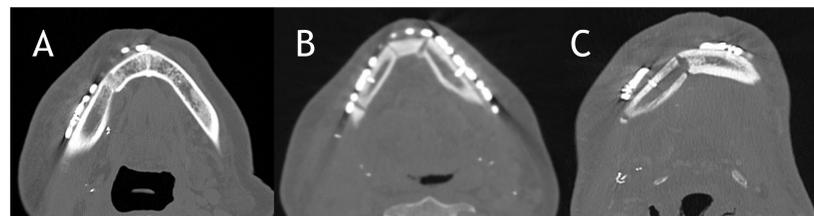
Post-operative CT scans showing appropriate bone segment fusion (A), partial/incomplete union (B) and nonunion (C).
